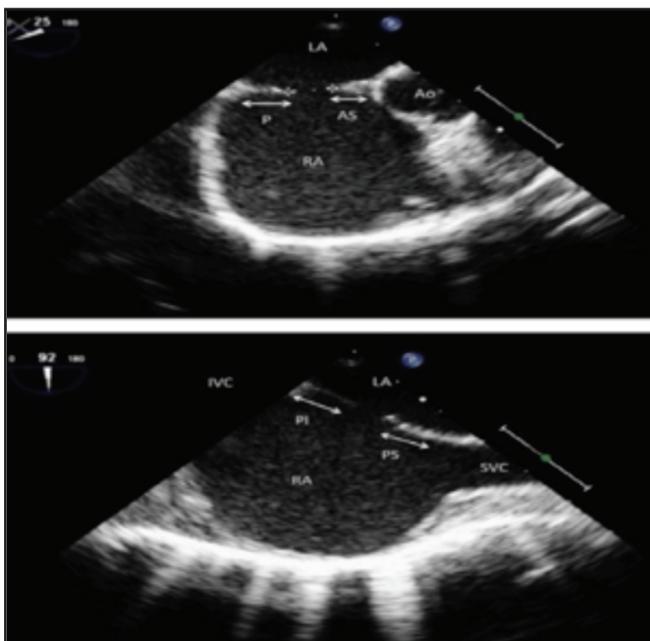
Echocardiogram revealing an ASD and VSD found in the patient.
